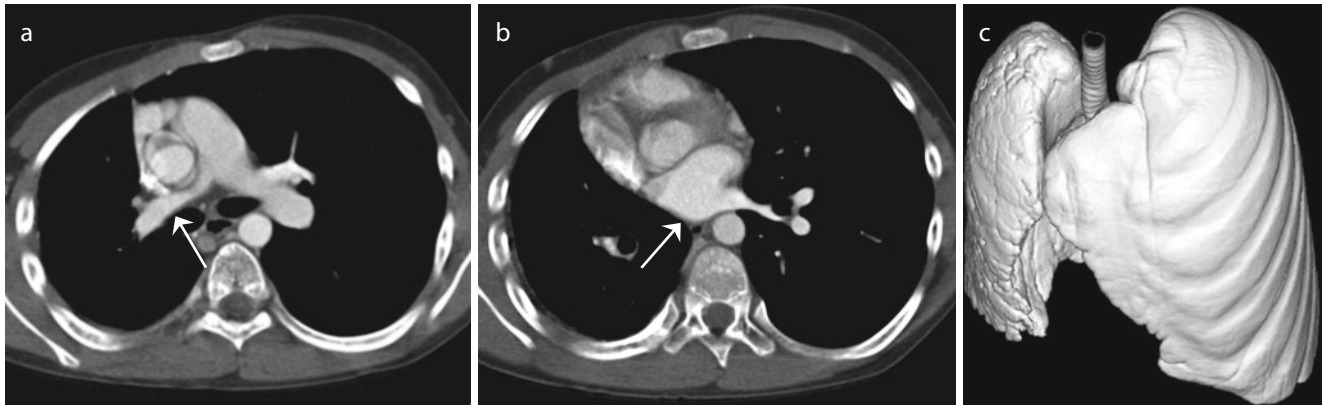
(a–c) Right pulmonary vein atresia. Axial CT image at the pulmonary artery bifurcation level shows the hypoplastic right lung and right pulmonary artery (*arrow*) (a). Axial CT image at the left atrial level additionally reveals the absence of the right pulmonary vein
